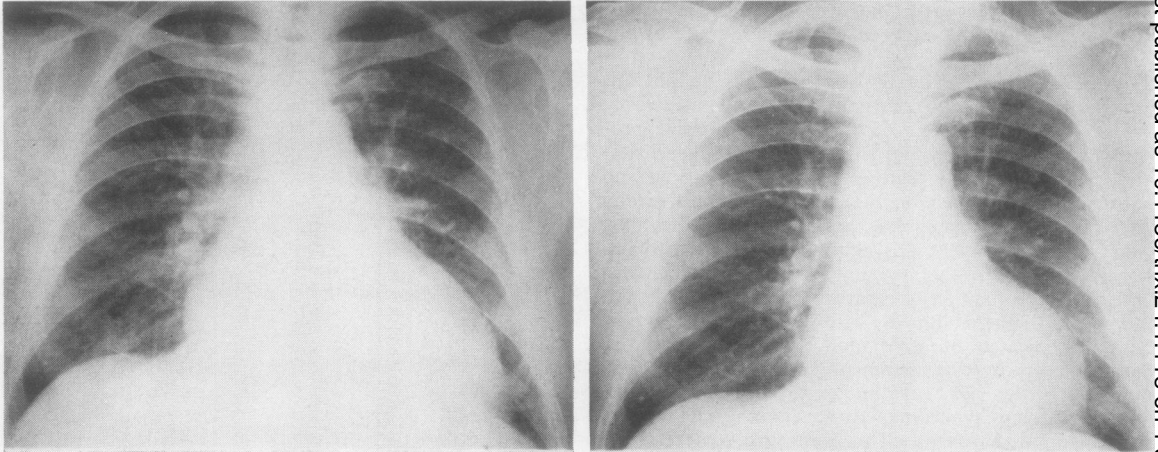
Chest radiographs (left) immediately before operation and (right) three months after surgery. In the post-operative film the heart has decreased in size and there is less plethora.
